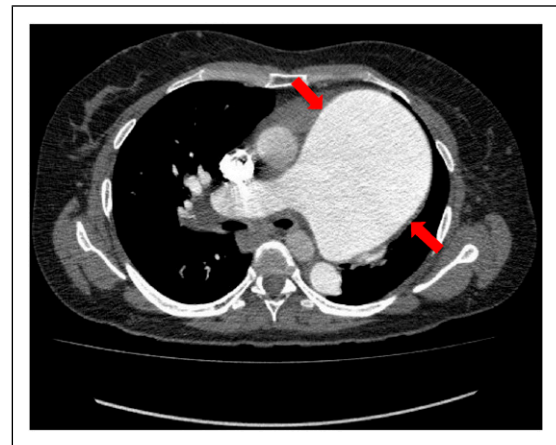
Axial section of contrast-enhanced computed tomography of the chest. The CT angiography of the chest revealed dilation of the pulmonary artery trunk, measuring up to 10.7 cm in diameter, compressing the left bronchus and showing signs of pulmonary hyperinflation on that side. CT performed in 2023.
